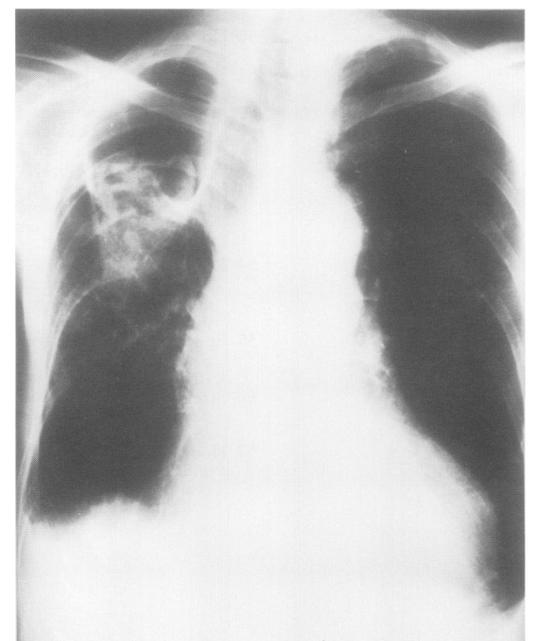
Radiograph of the chest obtained on admission to hospital. There is volume loss related to a previous right upper and middle lobectomy and a large right apical cavitation with pleural thickening. An irregularly shaped opacity extends inferiorly into the cavity.
